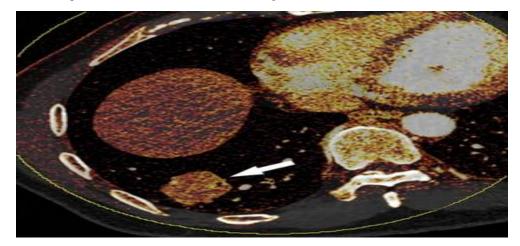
Blood pool defect in pulmonary blood volume map caused by lung carcinoma in 71-year-old man. Images were derived from dual-source CT-based dual-energy CT blood pool study of lung middle lobe.
